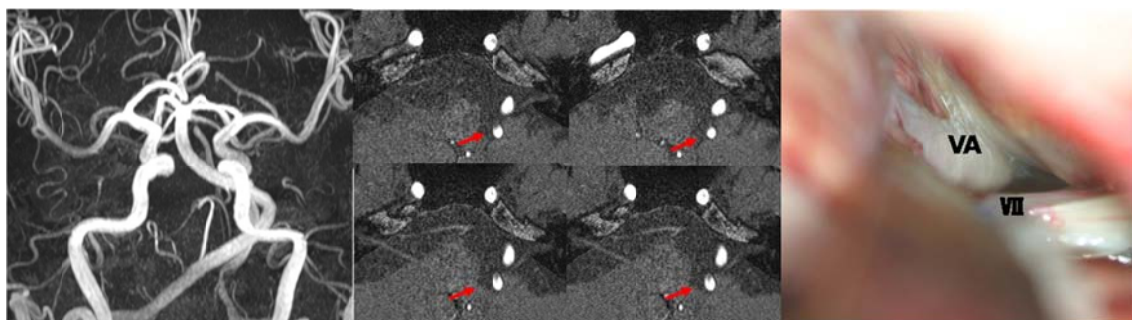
Preoperative MRI and photograph taken during surgery of a patient with right VA offender. The patient was 69 year old man with a left side facial spasm for 5 years. Preoperative MRI showed that right side VA compressed left facial nerve at the REZ (*red arrows*). Photograph was taken before neurovascular decompression. Surgical outcome was ‘good’ with permanent facial palsy. VA basilar artery, VII facial nerve
